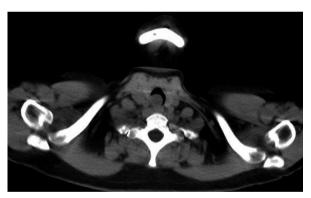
CT revealed a polypoid mass arising from the right posterior tracheal wall, occupying a large part of the tracheal lumen.
